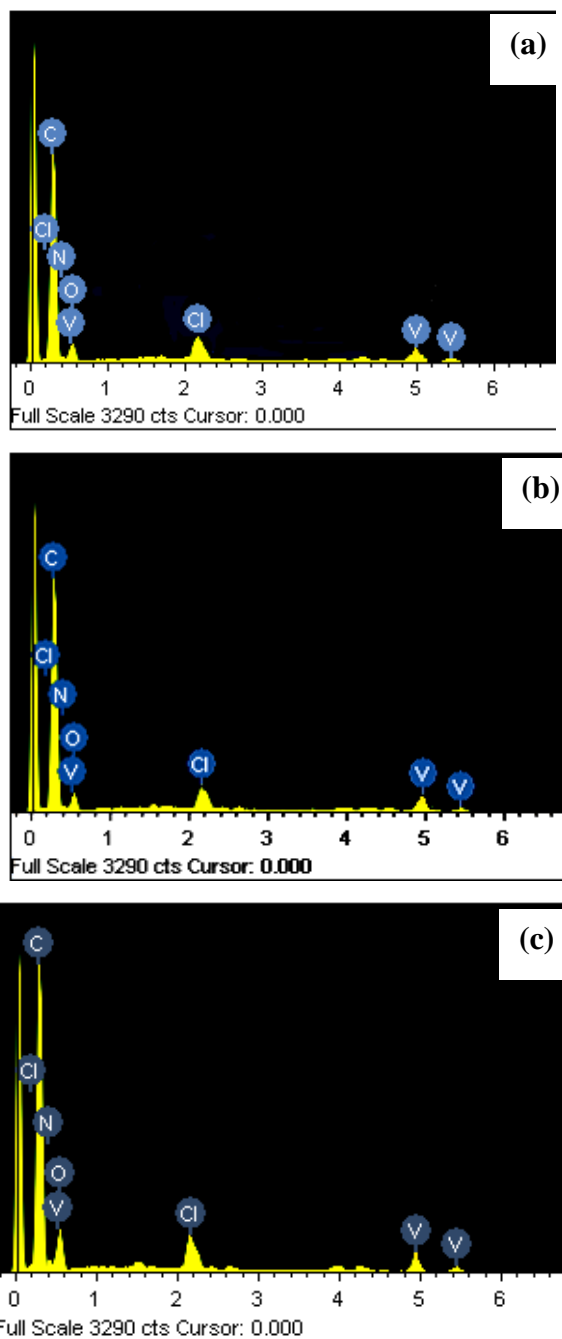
Energy-dispersive X-ray analysis (EDAX) profiles of (a) PS-im[V^VO₂(acpy-bhz)] (3.4), (b) PS-im[V^VO₂(acpy-inh)] (3.5) and (c) PS-im[V^VO₂(acpy-nah)] (3.6).
